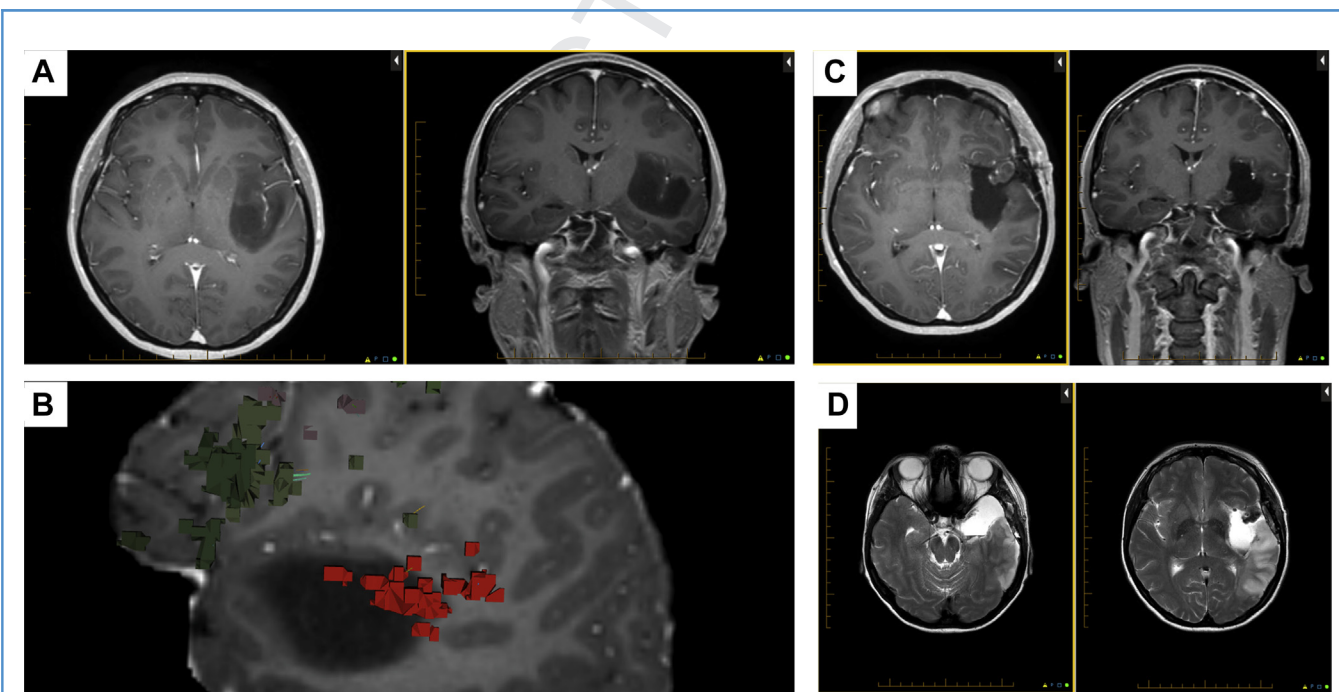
Resection of left insular glioma. (A) Axial (left) and coronal (right) T1-weighted gadolinium-enhanced magnetic resonance imaging (MRI) demonstrates an insular tumor with extension into the superior temporal gyrus. (B) Quicktome software demonstrates an expressive area (dark green) and receptive area (red) that are connected by arcuate fasciculus (not
